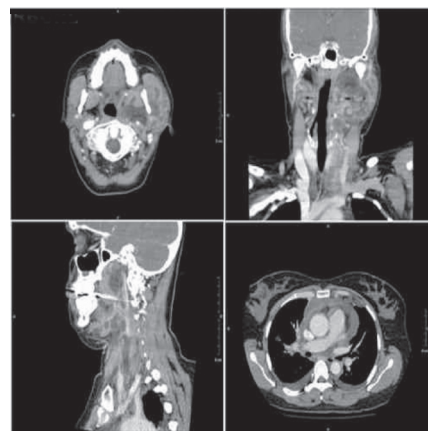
Computed tomography showing large abscess affecting multiple cervical spaces and extending into the anterior mediastinum.
